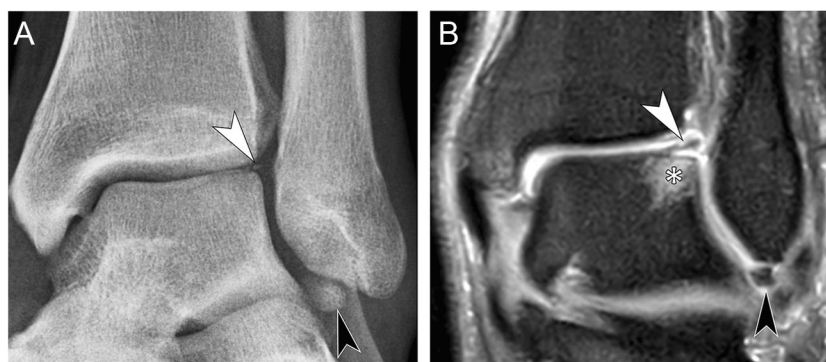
Acute osteochondral fracture of the lateral talar dome in a 22-year-old man with acute on chronic lateral ligamentous sprain. The mortise view radiograph (A) and coronal fat-suppressed proton-density-weighted MR image (B) of the ankle demonstrate an elevated
